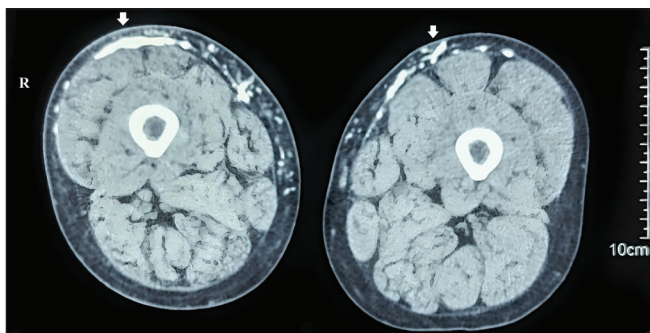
CT Scan: Axial section showing calcification (white arrows) in subcutis of lower thighs.
